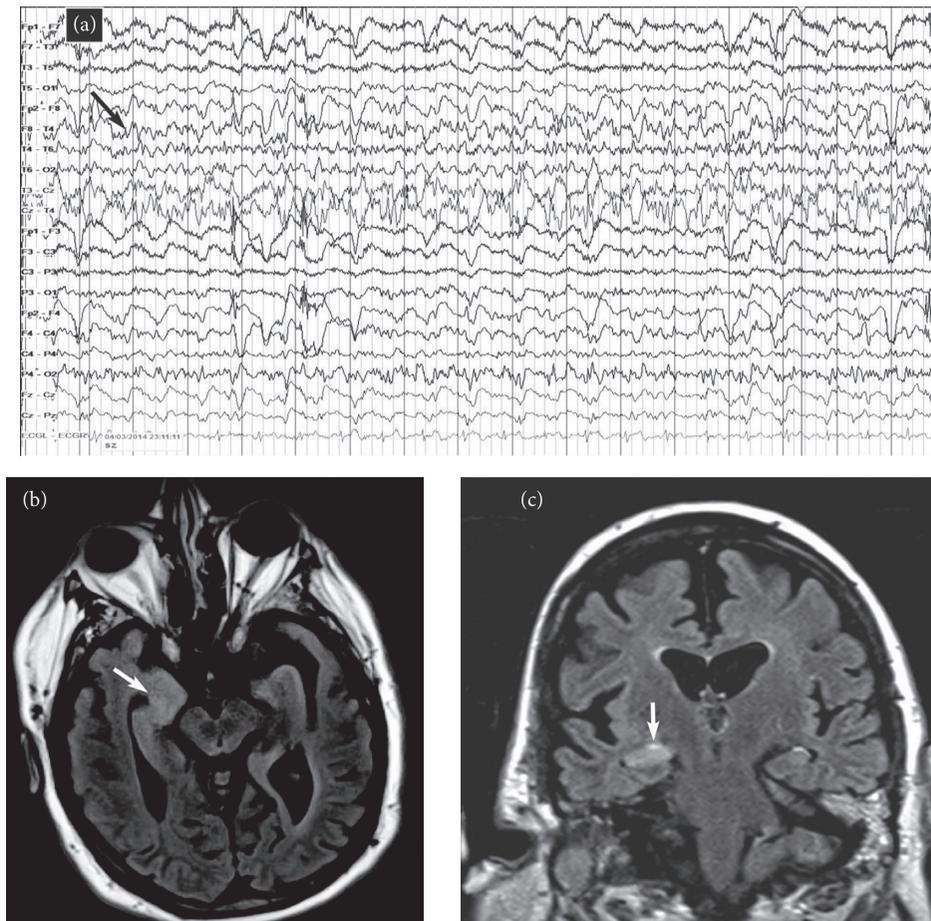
MRI changes associated with acute status epilepticus. A middle-aged man presenting with a previous history of epilepsy following a generalized tonic-clonic seizure. He failed to recover to baseline, and an urgent EEG was obtained that showed focal status epilepticus from the right temporal region (black arrow in (a)). MRI images obtained during the same admission showed an increased signal and swelling of the right hippocampus on axial (white arrow in (b)) and coronal (white arrow in (c)) FLAIR images.
